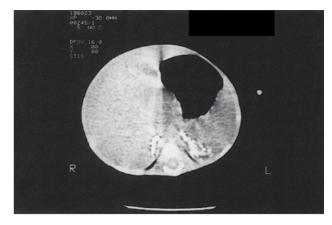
In this view, the CT scan clearly shows both adrenals to be densely calcified.
